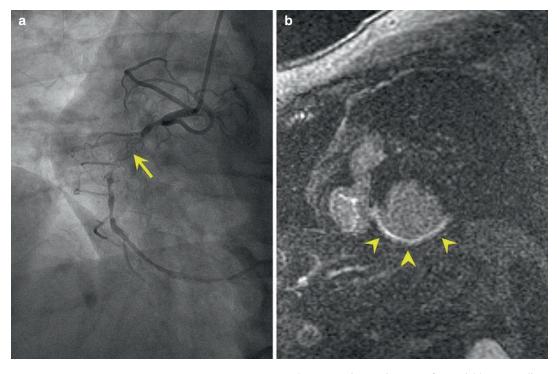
Representative myocardial viability study by MRI. Cardiac catheterization (a) demonstrates a total occlusion (arrowhead) of the right coronary artery (RCA). Assessment of viability was done by MRI. In the short axis view of the left ventricle by MRI, late gadolinium
